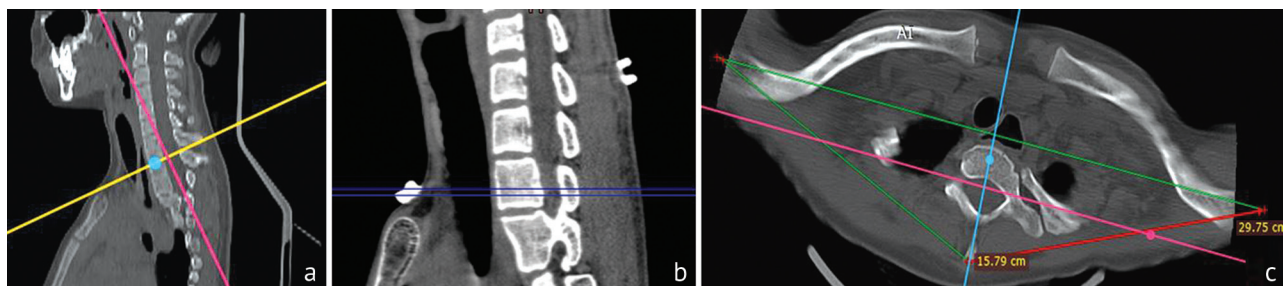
Verification of C7 and SJN markers radiographs (a, b) and CT scan (c)
